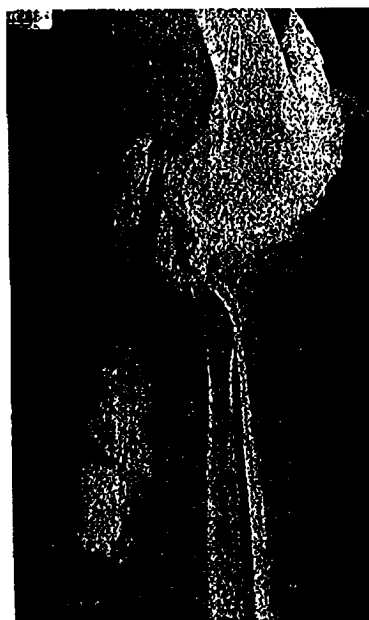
Ultrasound of a large popliteal cyst communicating with the knee joint (left). This technique has superseded arthrography (right) and the neck of the cyst (arrowed) communicating with the joint is clearly seen.
